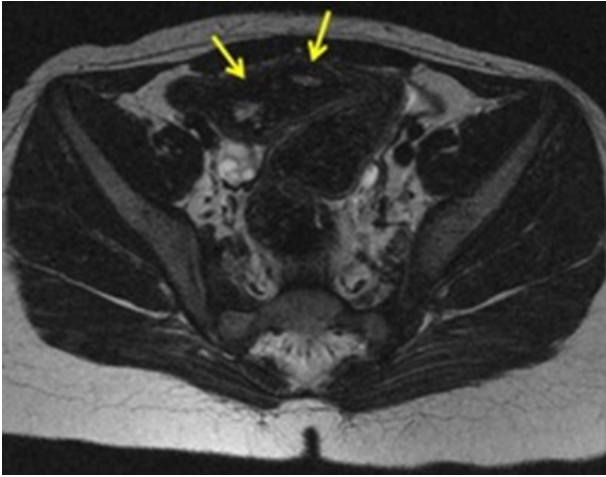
Axial T2-weighted image showing two hemi-uterus (arrows).
